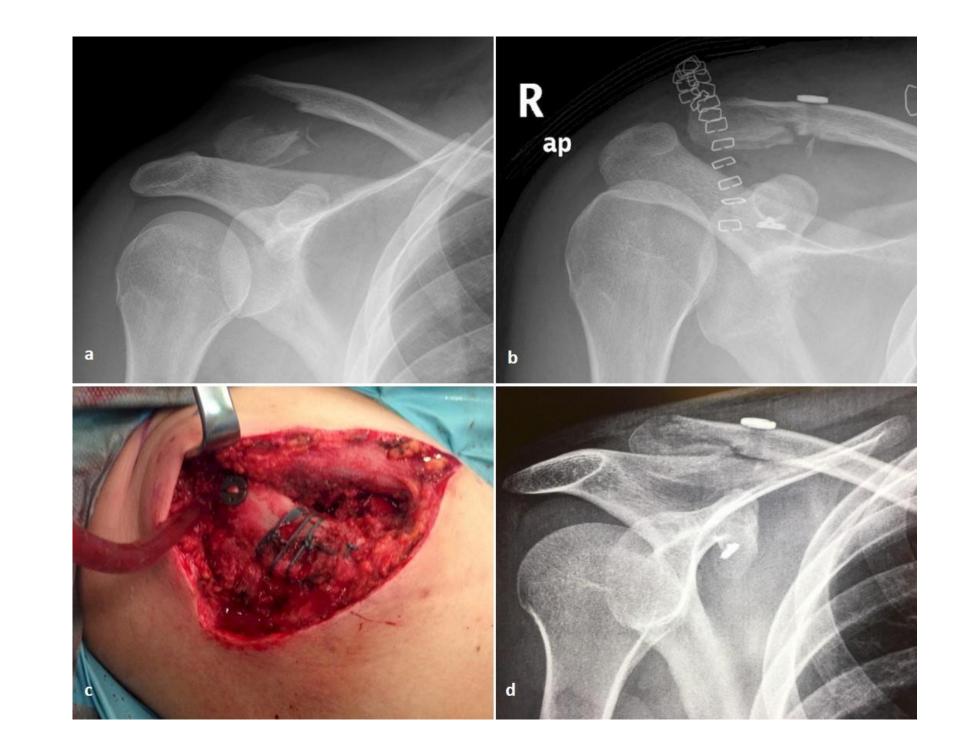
(a) Preoperative radiograph of an extra-lateral distal clavicle fracture with marked medial fragment displacement, (b) postoperative radiograph showing excellent reduction of the fragment, (c) final follow up radiograph showing maintenance of reduction and calcification of CC ligaments, a sign of adequate healing.
